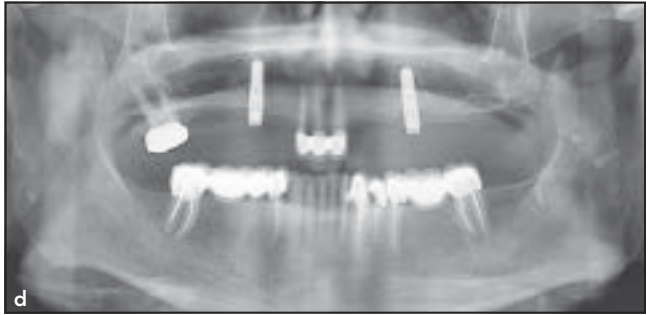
Patient 6 IARPD. (a) IARPD inserted. (b) Antagonist arch rehabilitated with fixed partial prosthesis. (c) Occlusion in maximum intercuspation. (d) Panoramic radiograph.
